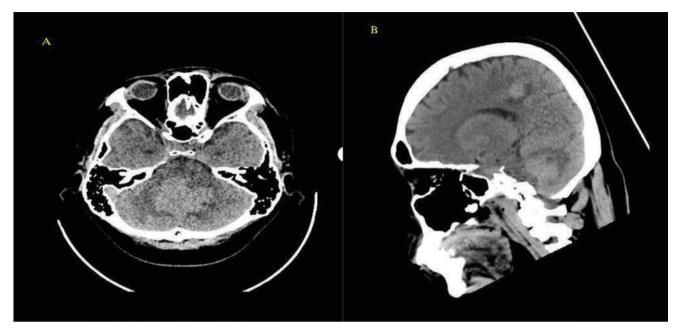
CT scan (axial view) (A) showing hyperdense lesion in the fossa posterior with (B) another hyperdense nodule in the subcortical area of the right parietal region
